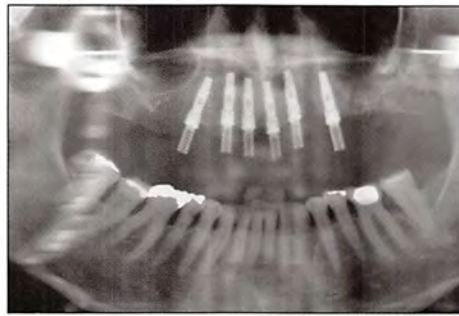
Panoramic radiograph of immediate screw-retained acrylic provisional at the time of implant placement.
